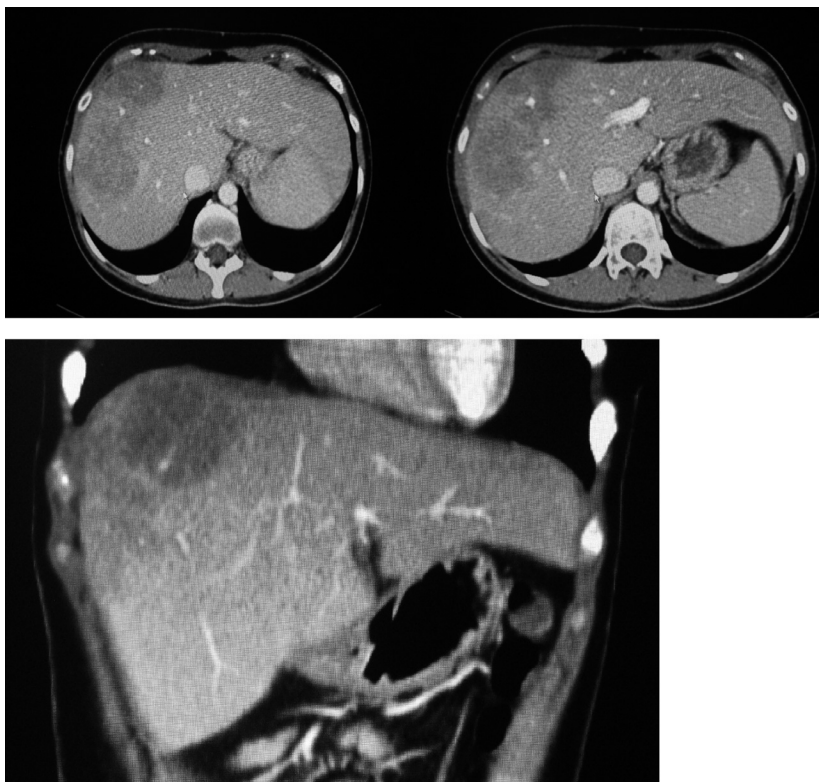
CT of abdomen shows several hypodense lesions in the right liver with confluence into a single lesion (10 × 6 cm).
